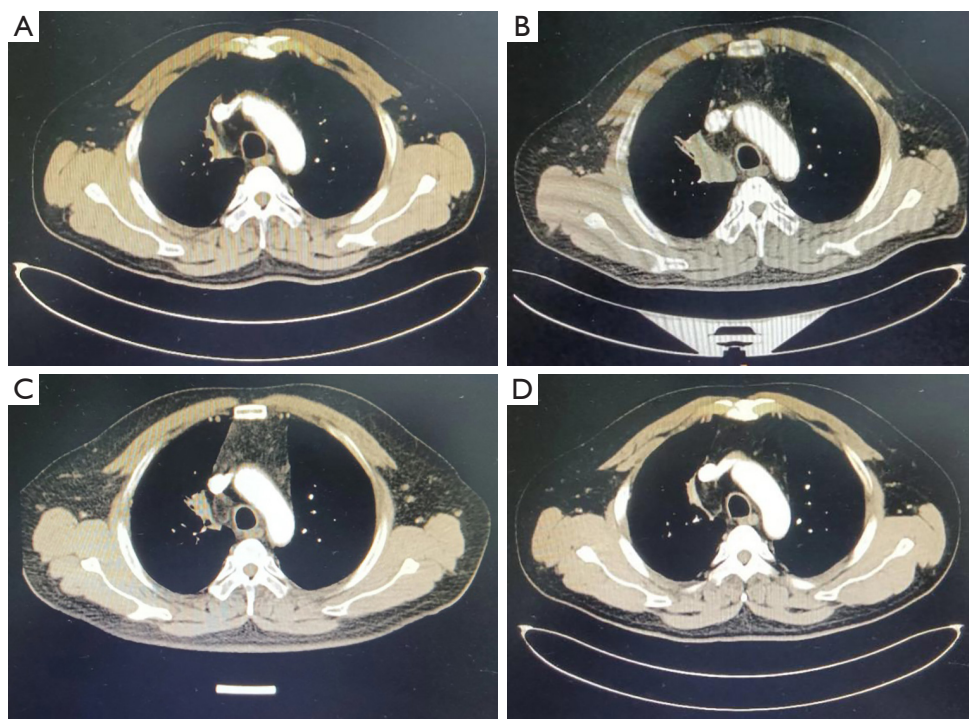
Chest CT. (A) After 2 cycles of albumin-binding paclitaxel + carboplatin combined with pembrolizumab (2021-11-03). (B) After 4 cycles of albumin-binding paclitaxel + carboplatin combined with pembrolizumab (2022-01-11). (C) After 2 cycles of docetaxel + carboplatin combined with pembrolizumab (2022-03-15). (D) After 4 cycles of docetaxel + carboplatin combined with pembrolizumab (2022-05-17). CT, computed tomography.
